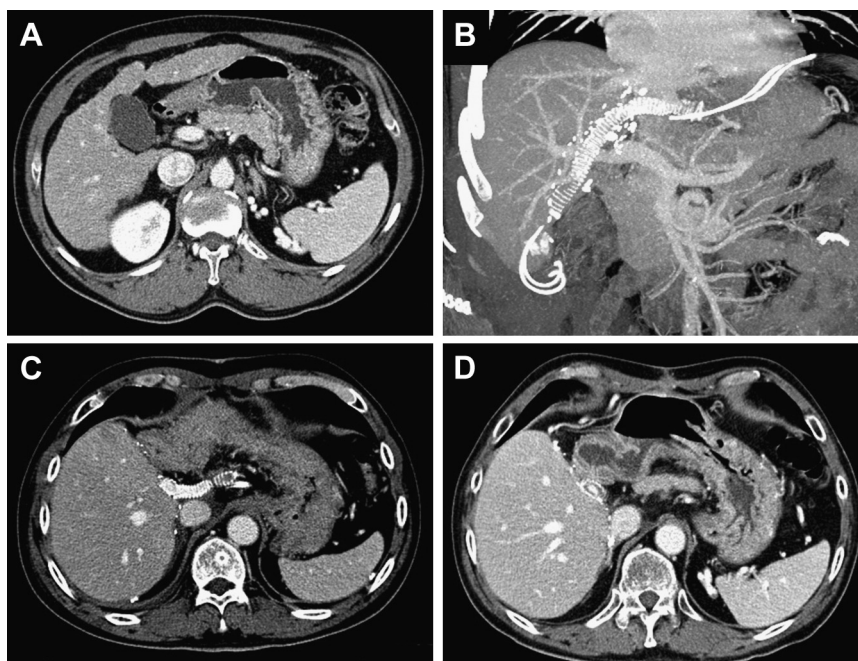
Computerized tomographic (CT) follow-up before PTFE graft migration. Native cirrhotic liver (A) was removed and a right liver graft implanted. Follow-up CT images showed patent PTFE graft of middle hepatic vein reconstruction at post-transplantation 1 week (B and C) and 3 months (D).
